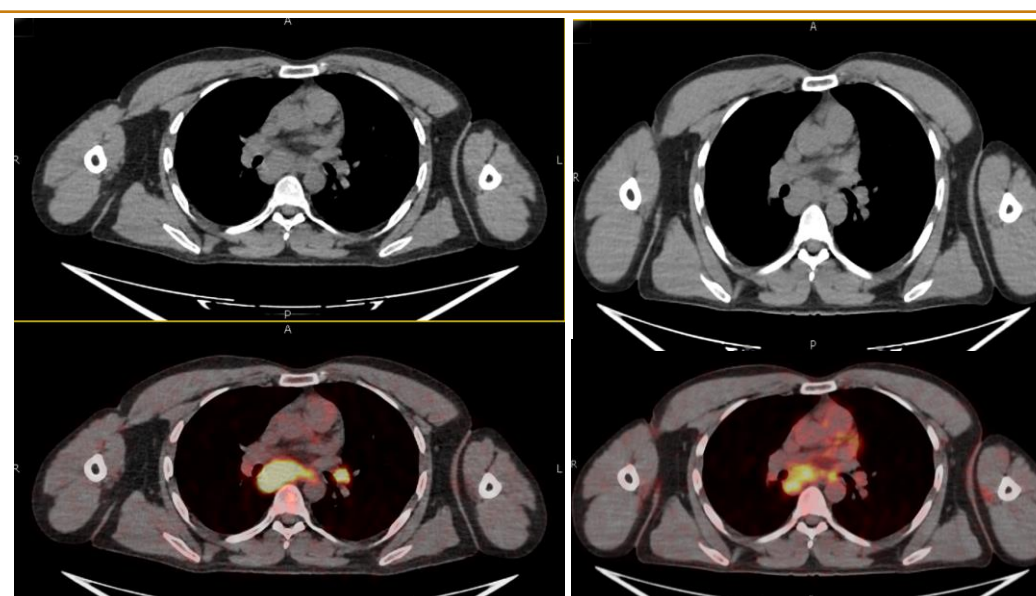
Persistent functional activity identified in the sub-sternal lesion which appears to have decreased in size on CT; Partial Metabolic Response (PMR).
